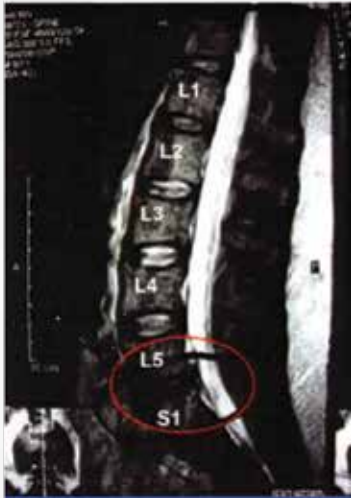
Post-treatment MRI (03/14/05)
